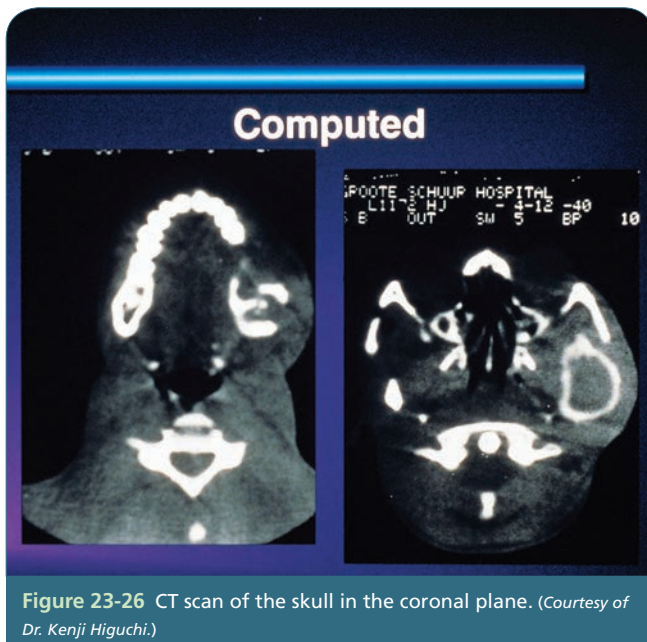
CT scan of the skull in the coronal plane. (Courtesy of Dr. Kenji Higuchi.)
